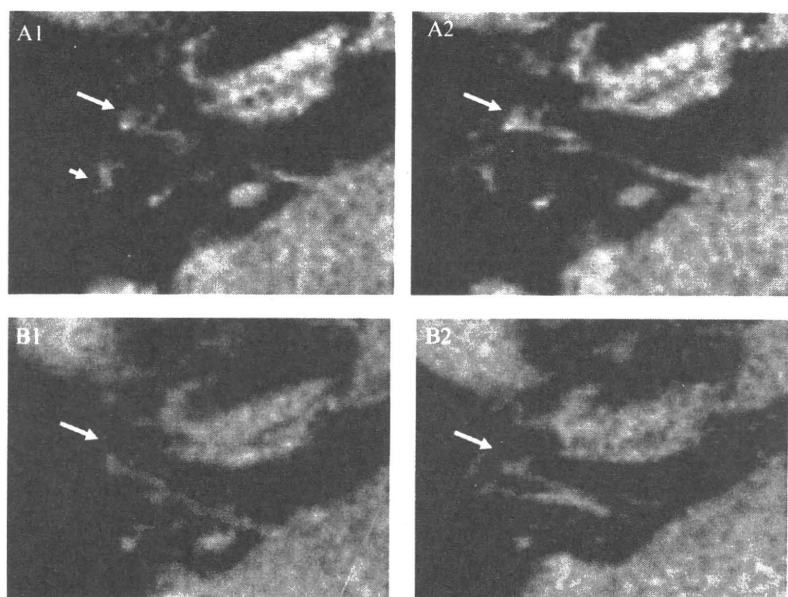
Axial magnetic resonance image. Right inner ear of a 45-year-old man with vertigo and right sudden sensorineural hearing loss. (A1) First three-dimensional fluid-attenuated inversion recovery (3D-FLAIR) image before enhancement. Bright signals are very high in right cochlea (long arrow) and vestibule (short arrow). (A2) First 3D-FLAIR image after enhancement. Gadolinium enhancement is not observed in right cochlea (long arrow). (B1) Second 3D-FLAIR image before enhancement. No bright signal is visible in right cochlea or vestibule. (B2) Second 3D-FLAIR image after enhancement. No gadolinium enhancement is visible in right cochlea.
